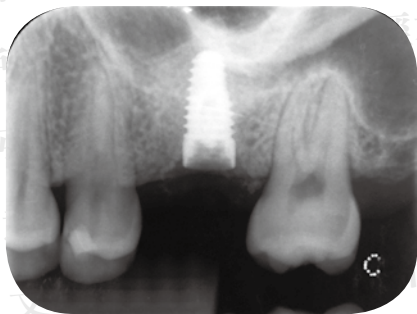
Radiograph of the fractured abutment screw after crown removal. It demonstrated that the failed abutment screw remained within the implant body.
